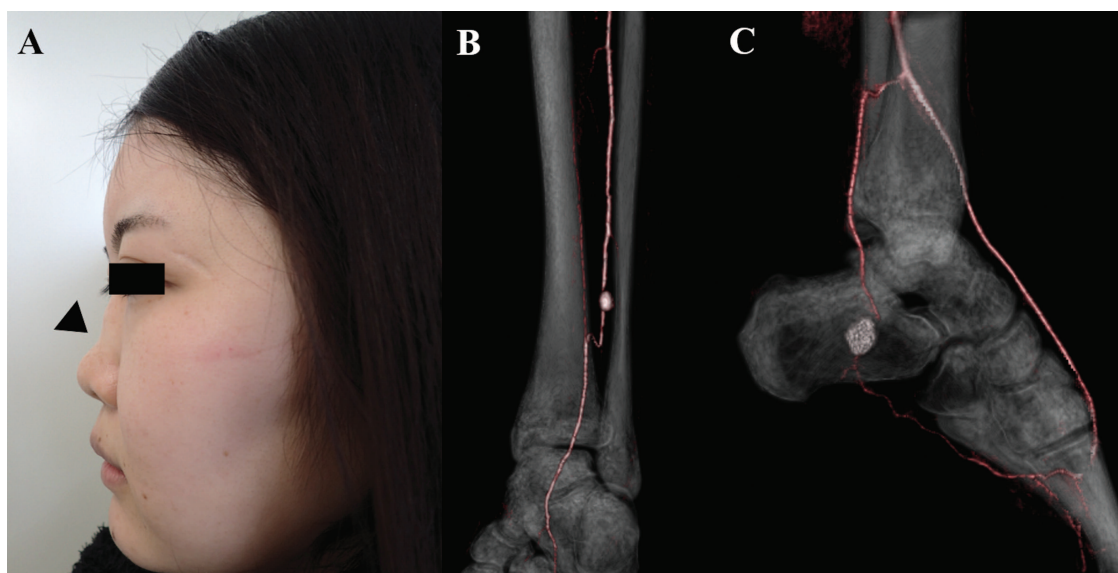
A. Saddle nose is observed (arrowhead). Computed tomography angiography reveals aneurysms in left posterior tibial artery (B) and right peroneal artery (C).
